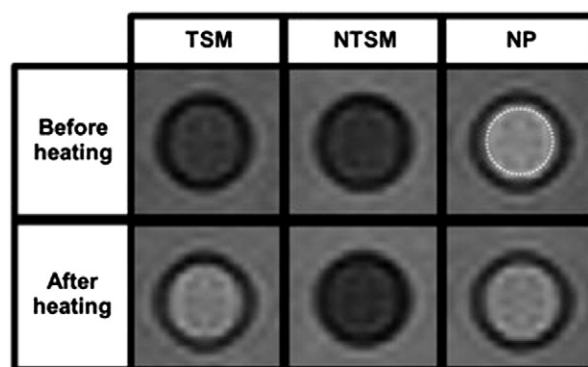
T_1 -weighted gradient echo images (echo time 10 ms) before and after heating to 45 °C using a waterbath for thermosensitive liposomes (TSM), non-thermosensitive liposomes (NTSM) and free iron oxide particles (NP). A clear MRI signal enhancement of $83 \pm 4\%$ is shown for TSM. Reprinted with permission from Wiley [130].
